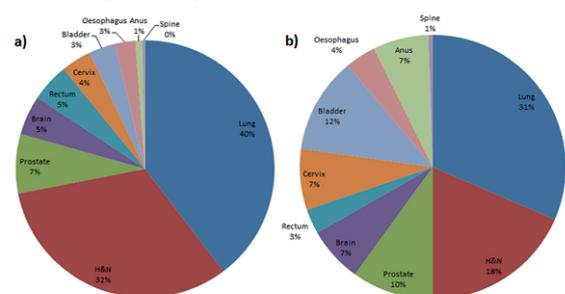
a) The percentage of patients requiring physics attention for CBCT review and b) the percentage of patients that had a replan by site
